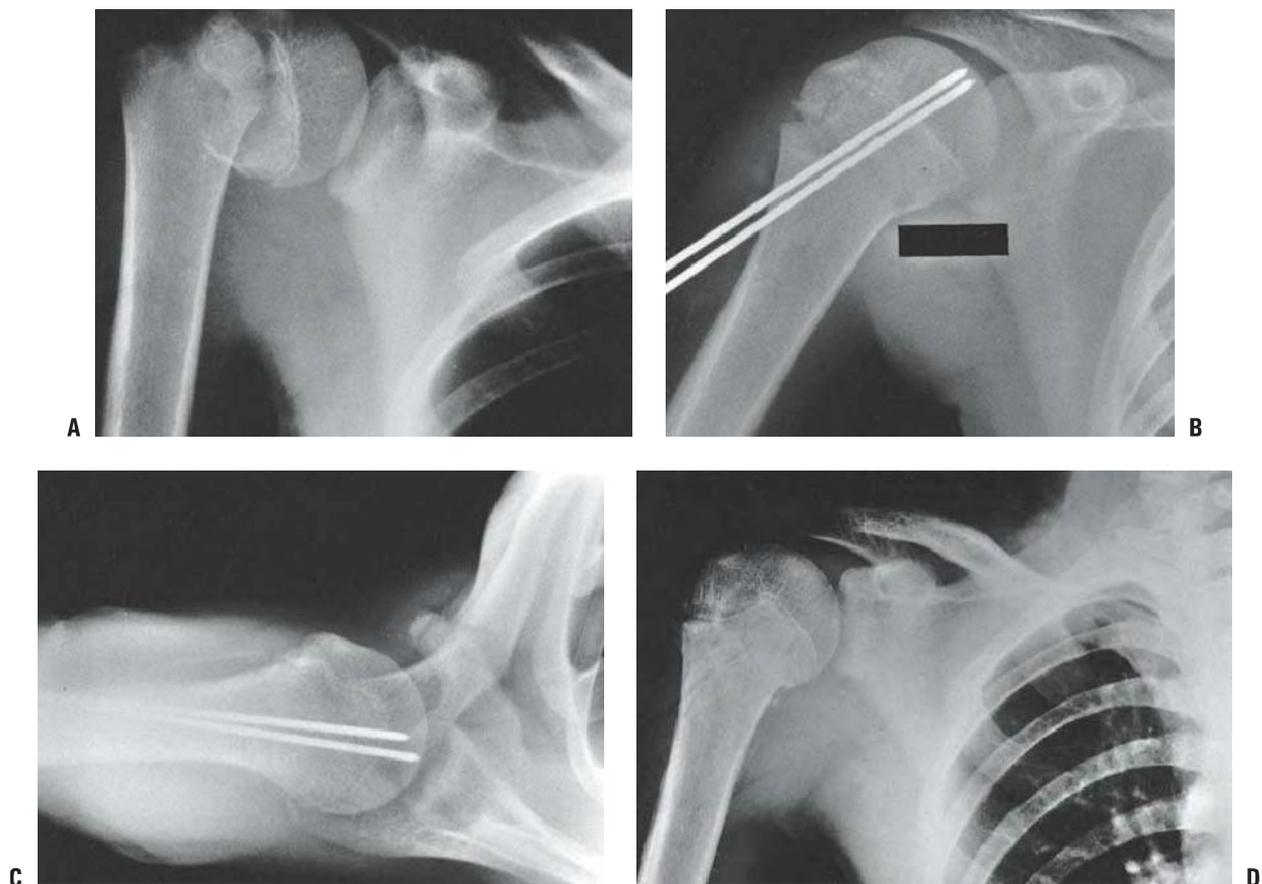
Salter-Harris type II fracture of the proximal humerus in a 15-year-old adolescent. A: Displaced fracture with 70 degrees of angulation. The proximal fragment is abducted and externally rotated because of the rotator cuff attachments. The shaft is displaced proximally by the pull of the deltoid muscle and is generally adducted by the action of the pectoralis muscle. The distal fragment is also internally rotated if the arm is placed in a sling. B, C: AP and lateral radiographs after CRPP. The arm is externally rotated and abducted with longitudinal traction to achieve this position. D: Final alignment after removal of the pins 4 weeks later.
